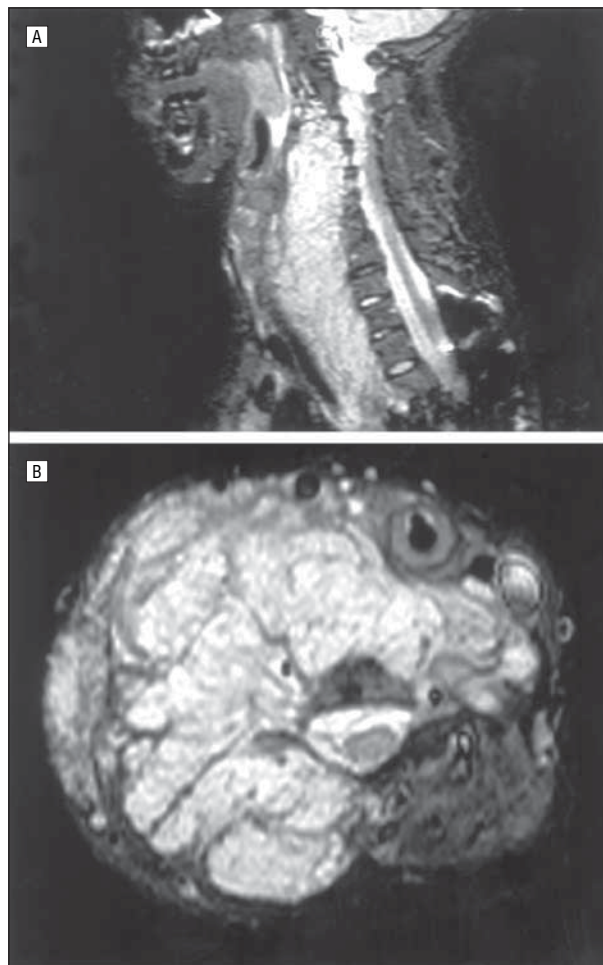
Patient 2, a 13-year-old boy, had a massive right-sided plexiform neurofibroma originating from the cervical spine. A, T2-weighted magnetic resonance (MR) image in the sagittal plane reveals a massive tumor extending from skull base to mediastinum, with frank tumor invasion of the foramina of C2 through C6. B, T2-weighted MR image of the axial plane demonstrating large tumor burden throughout the neck (greater on the right side than on the left) with resulting airway deviation.
